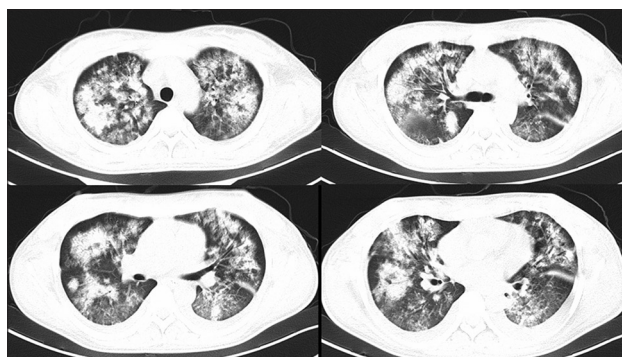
Computed tomography of this patient showed diffuse interstitial infiltrates along with patchy lesions characterized by poorly defined nodules, air-space consolidation, interlobular thickening, and ground-glass opacity.
